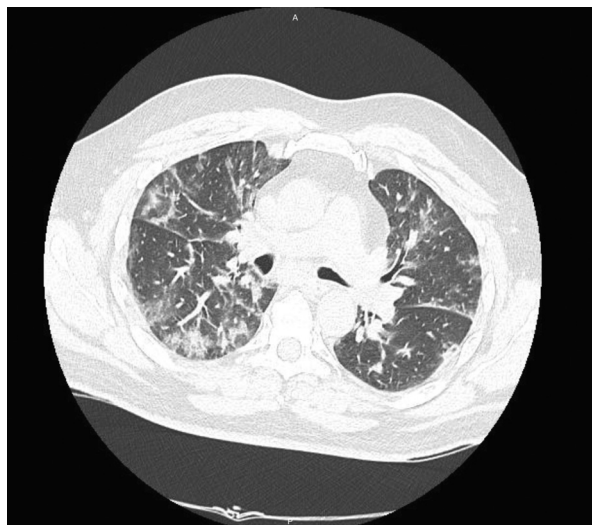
Case 17. Chest computed tomography. Changes in the course of COVID-19. The thoracic computed tomography revealed peripheral inflammatory lesions of matt glass and paving stones, taking up about 8% of the lungs.
